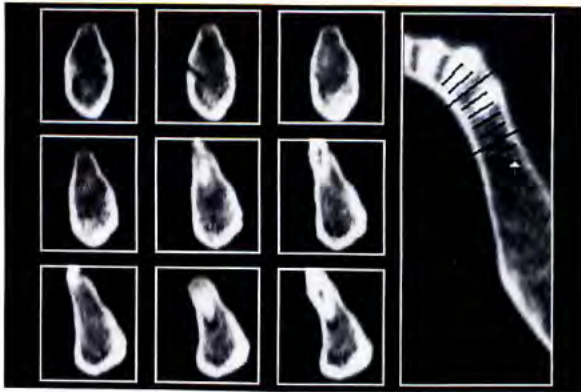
Cross-sectional image. One of the set-of-three images reformatted by the CT scanner.
